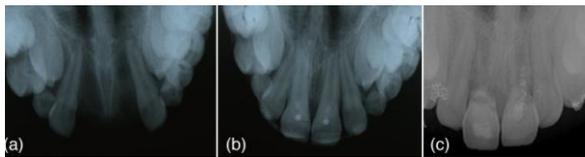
Radiographic view of the 8-years-old male patient a) Avulsion of upper central incisors b) Replanted incisors stabilized with fiber splint c) Complete root resorption of the central incisor after 2 years
